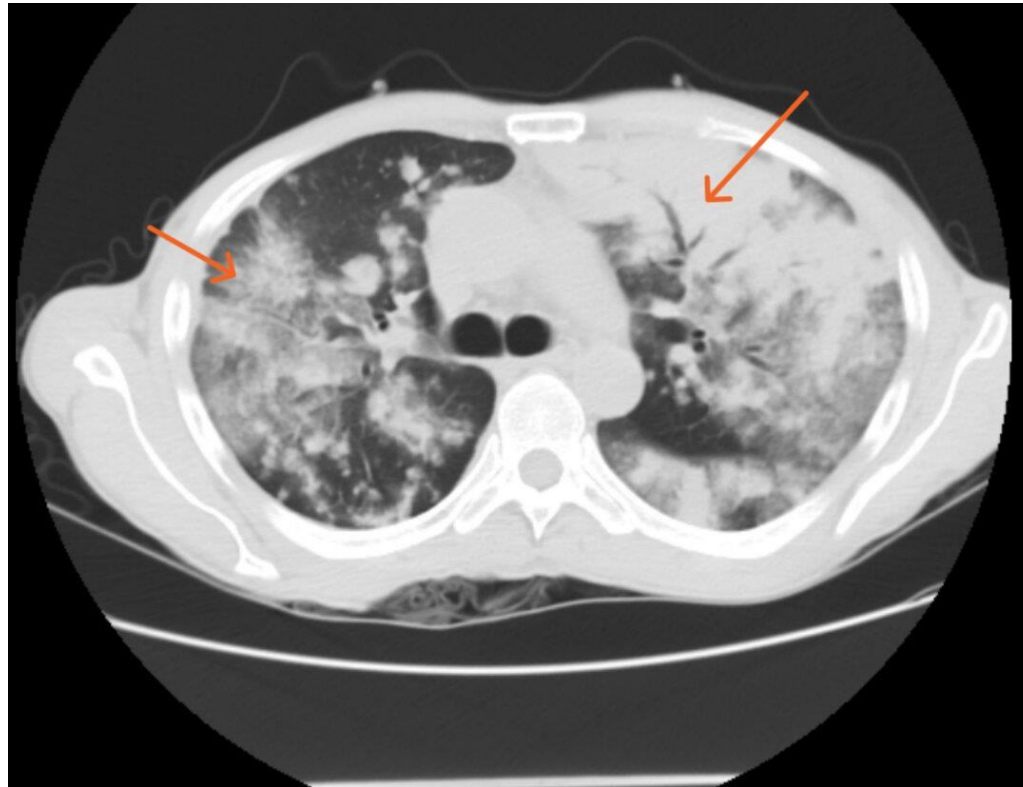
CT Thorax in the lung window showing bilateral fluffy opacities with air-bronchograms, suggestive of fungal pneumonia
